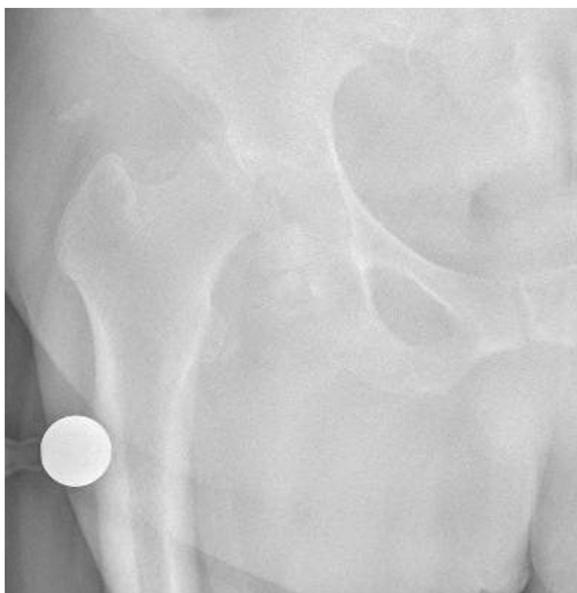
Case 2; Anteroposterior and lateral hip radiographs displaying right femoral head resorption following an intra-articular corticosteroid injection.
